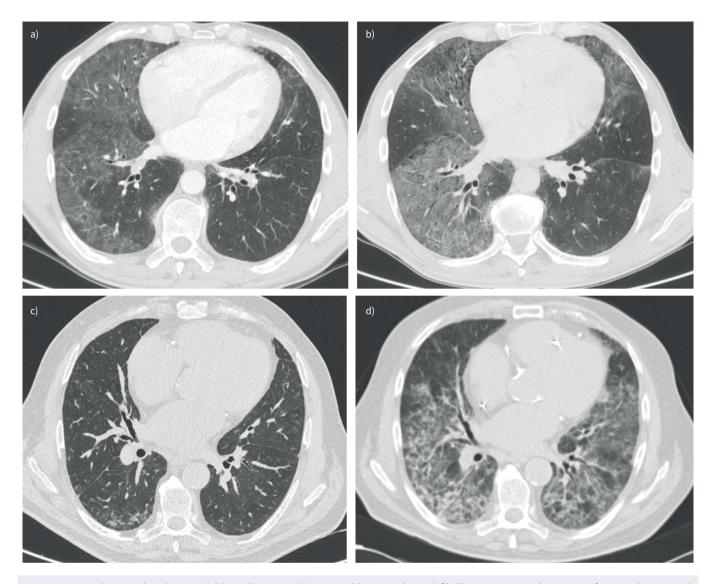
Amiodarone-induced interstitial lung disease. a, b) 48-year-old man with atrial fibrillation. Lung window images from axial computed tomography (CT) show a) extensive ground-glass opacities identified after 2 years of treatment with amiodarone; b) after 1 year, despite drug discontinuation and initiation of glucocorticoids, ground-glass opacities became more extensive. c, d) 77-year-old man with atrial fibrillation. High-resolution CT c) before and d) 1 month after initiation of amiodarone. Axial CT shows extensive ground-glass opacities and increased interstitial markings.
